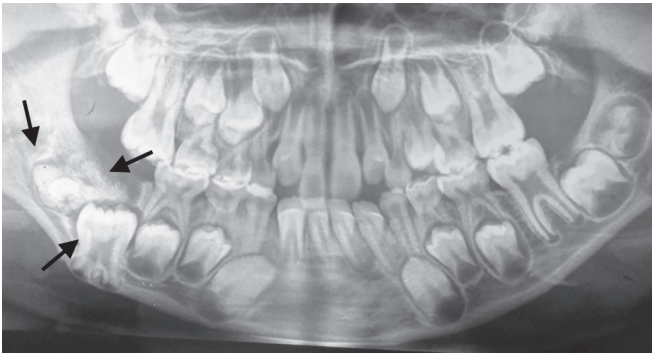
Panoramic radiograph showing well-demarcated radiolucent lesion affecting the right lower permanent molar region, containing radiopaque areas of varying size, causing the displacement of the tooth germ of the lower first molar
